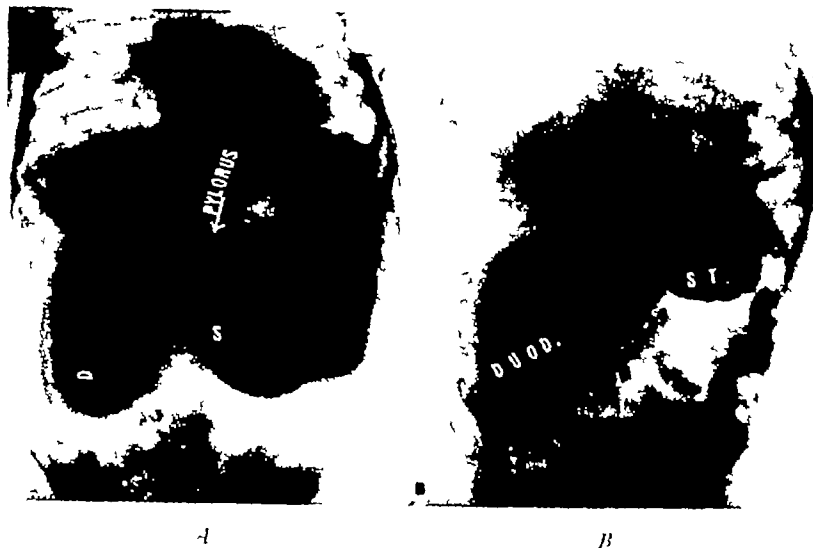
Congenital dilatation of duodenum. Male 4 years 6 months of age. Periodic vomiting abdominal distention. Radiographic examination showed an enormous pouch to the right of the stomach and equal to it in size (A). The stomach was almost empty at the end of six hours, but the duodenum was more distended than before (B). The duodenum was still filled at the end of 24 hours. Diagnosis of dilated duodenum due to congenital obstruction was made. Successfully operated upon by Dr W. A. Downes.
